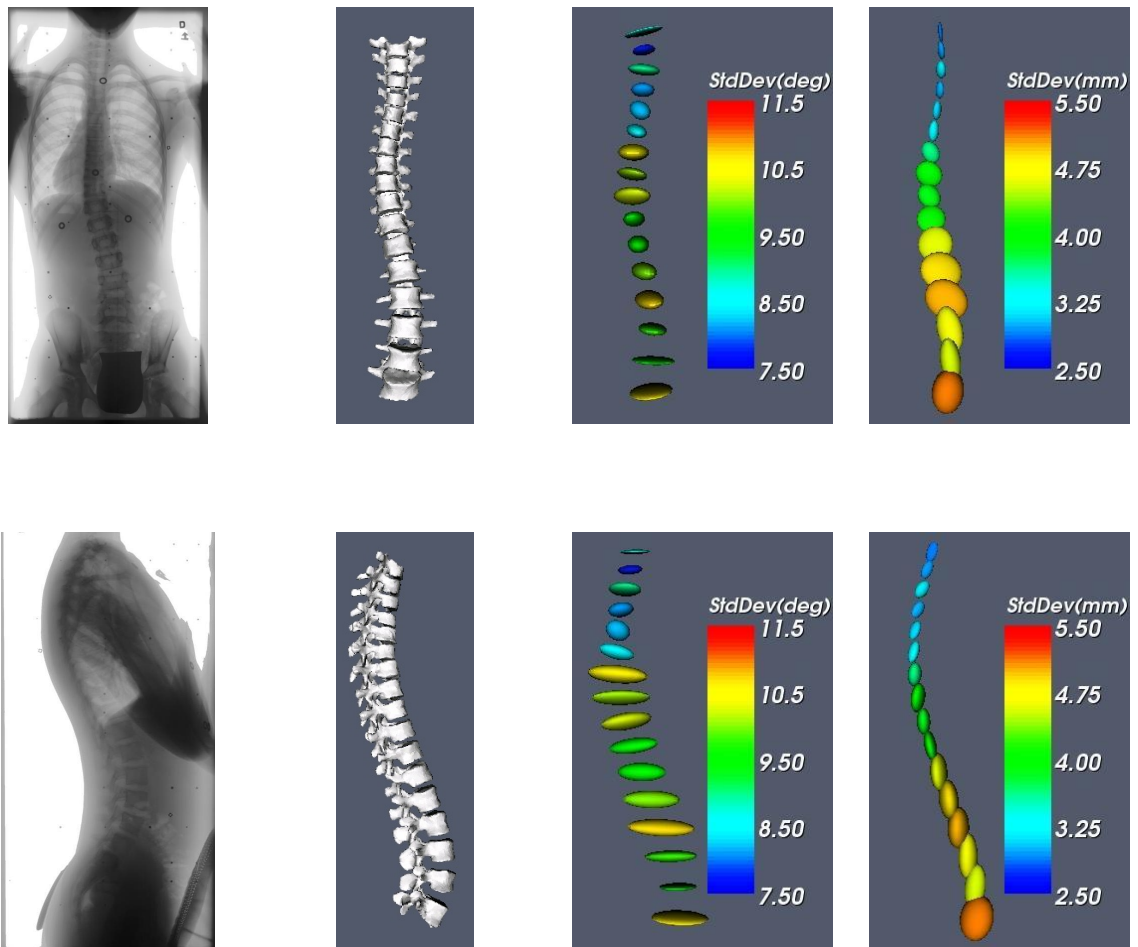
Statistical spine model. From left to right: Example of a Bi-planar radiographs of the human trunk, mean spine model, rotation and translation covariance. Top: Postero-anterior view. Bottom: lateral view.
